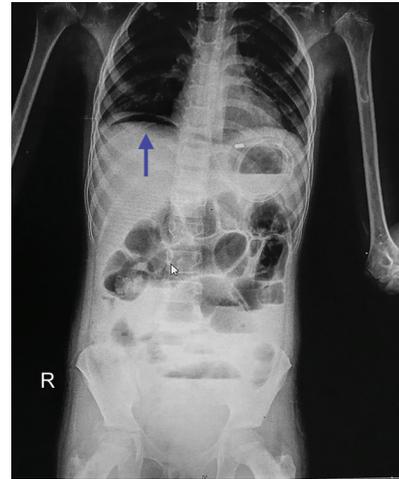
Abdomen X-ray on POD 18 showing reduction in air-fluid levels and decreased free air under the diaphragm with conservative management
